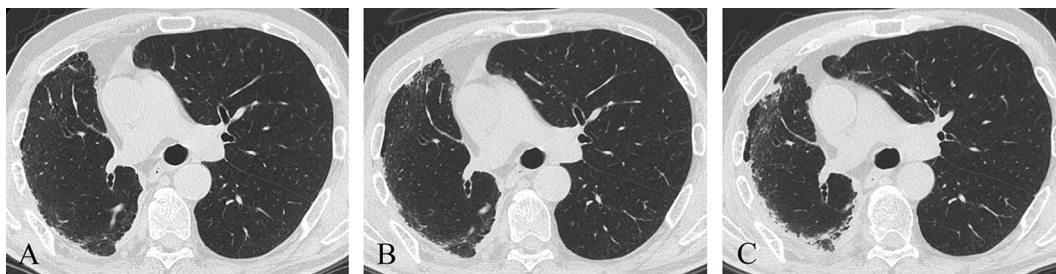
High-resolution computed tomography (HRCT) after the first surgery. Ground-glass opacities appeared along the subpleural area of the right residual lung 20 months after the first surgery (A), and then gradually changed to consolidation with bronchiectasis on HRCT: 26 months after the first surgery (B); 38 months after the first surgery (C).
